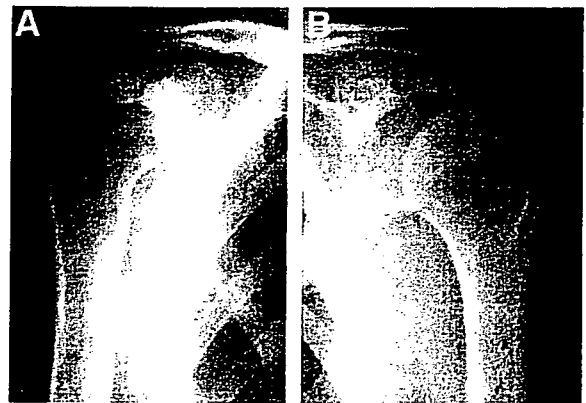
Radiographs of the rheumatoid shoulders of a 62-year-old woman. A, The right shoulder was at grade 5, and had mild GTD. It showed extensive osseous lesion in the articular surface, but there was little osseous lesion in the greater tuberosity. The destruction pattern was GHD, uniformly mild type. The destruction was asymmetrical. B, The left shoulder showed no pronounced lesion and was at glenohumeral joint destruction (GHD) grade 1. It had a mild grade of greater tuberosity destruction (GTD).
